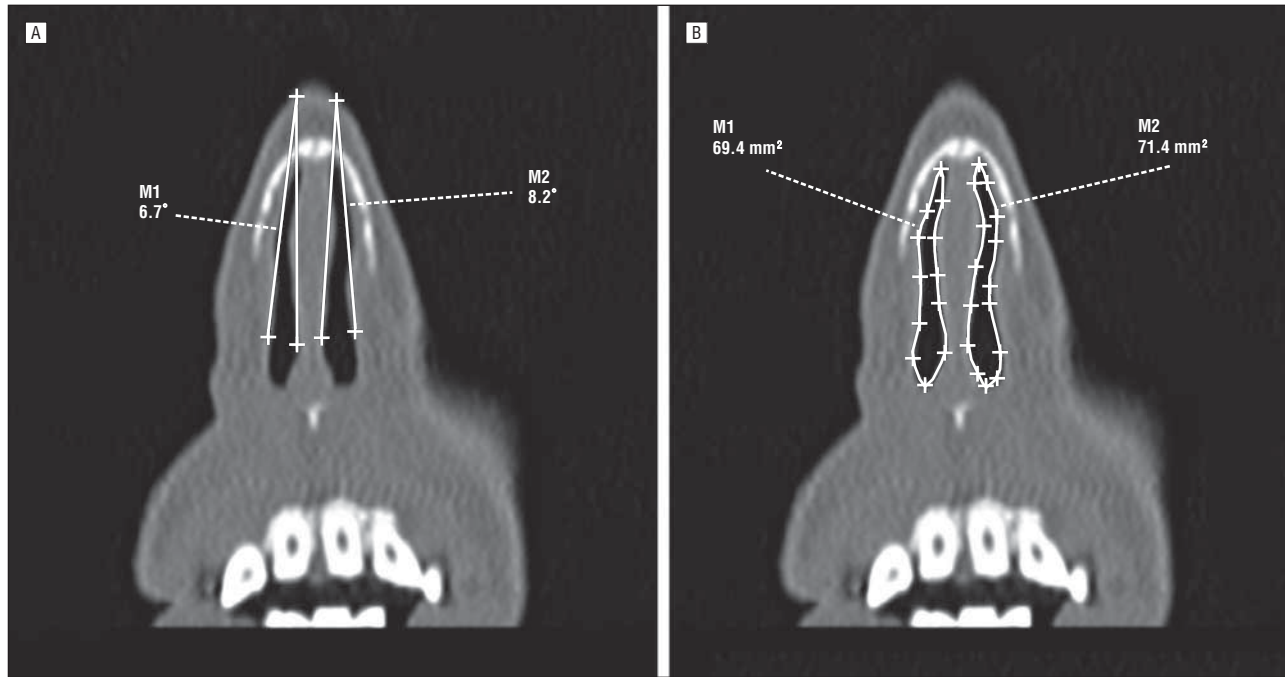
Computed tomograms of the internal nasal valve region. A, Measurement of the internal nasal valve angle according to the standard coronal plane orientation. B, Measurement of the cross-sectional area of the internal nasal valve region in the same patient, with the scan oriented in the standard coronal plane orientation. M1 indicates right nasal cavity; M2, left nasal cavity.
